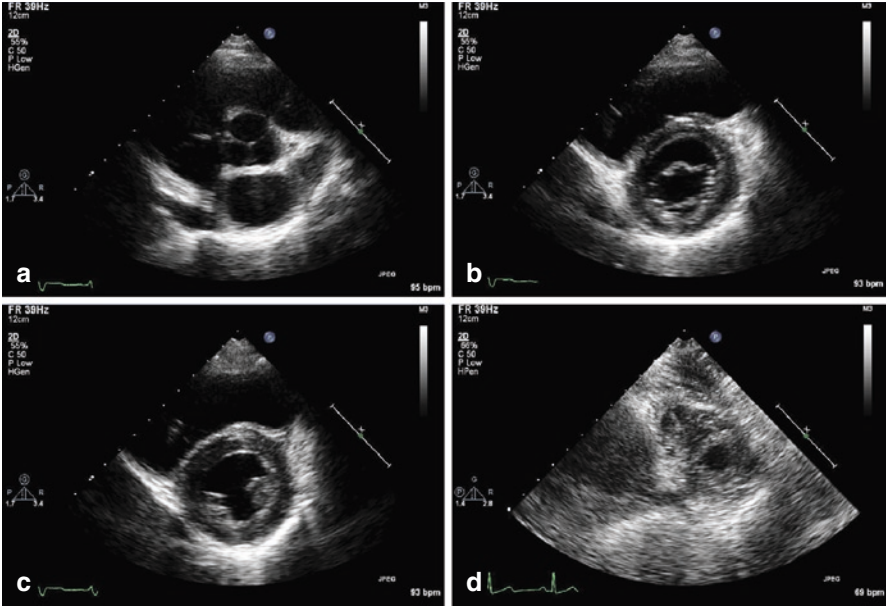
Parasternal short axis (PSAX) view. The PSAX view is obtained by remaining in the parasternal window and rotating the transducer clockwise approximately 90°. Sweeping the transducer from base to apex results in: (a) the basal level view, (b) the mitral level view, (c) the papillary level view, and (d) the apical level view. In the basal and mitral level view, color flow Doppler can be used to assess the valves for regurgitation
